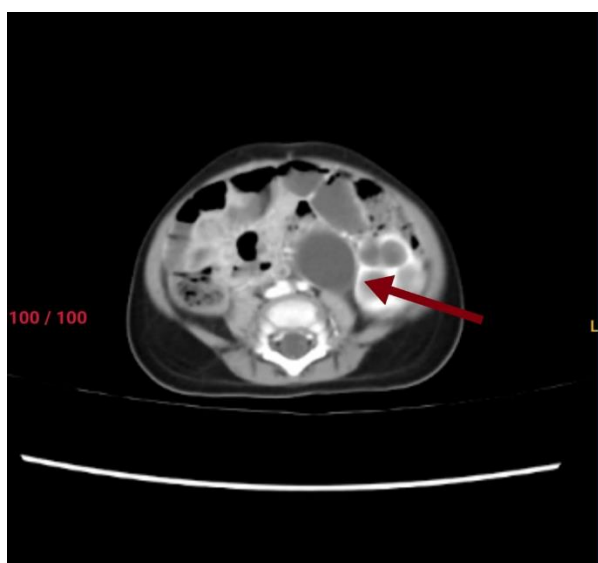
CT urography showing the gross enlargement of the left kidney with reduction of cortical thickness and giant pelvis and ureter.
